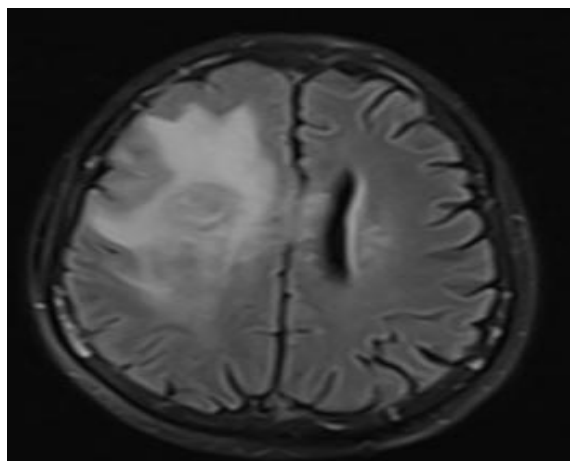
MRI revealed a right frontal lobe tumour with surrounding oedema.
